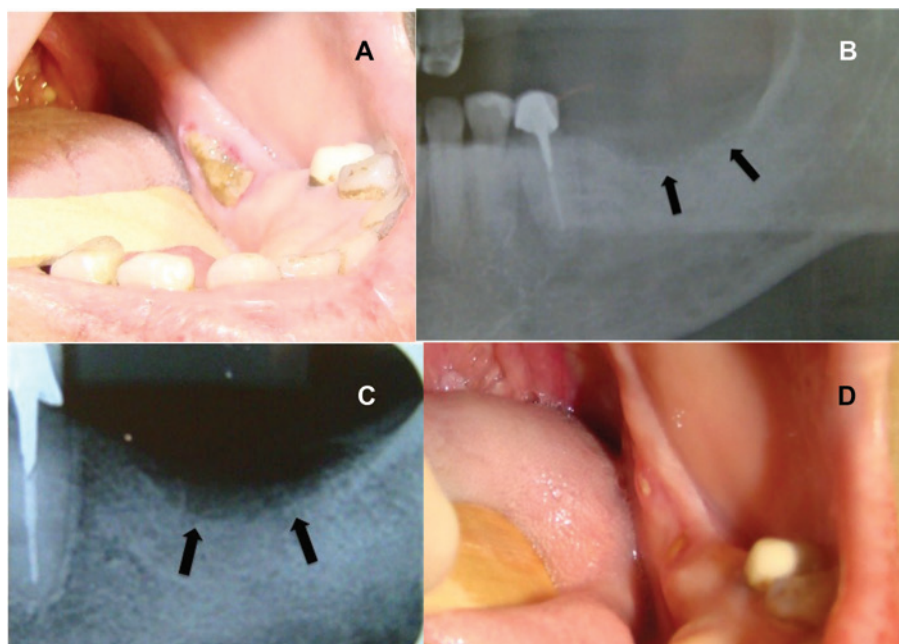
(A) Initial clinical aspect of BRONJ with necrotic bone exposure and erythematous surrounding mucosa. (B) Panoramic radiograph showing osteolysis area (arrows). (C) Periapical radiograph showing osteolysis area (arrows). (D) Clinical aspect after 54 days of LLLT showing partial reepithelization of the lesion.
